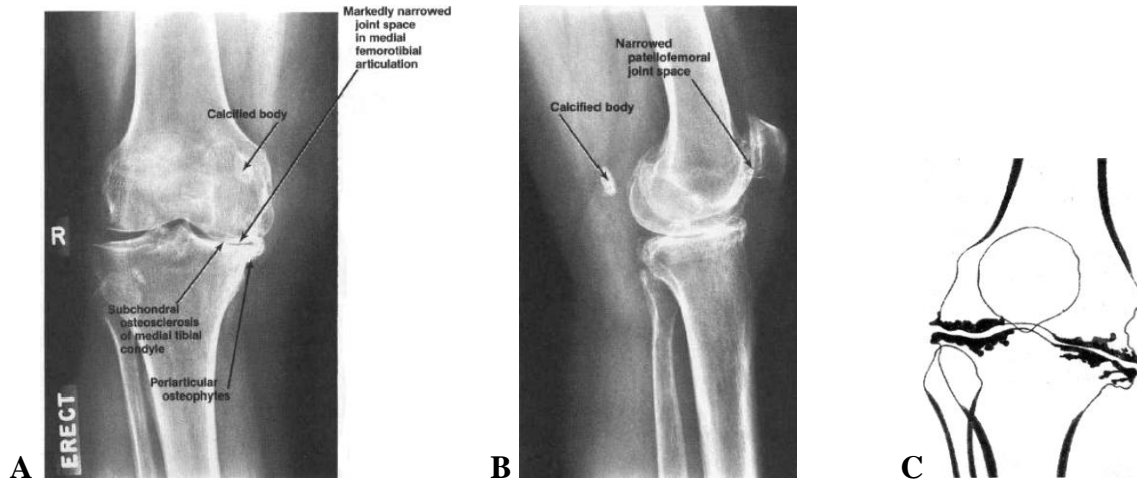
The frontal (A) and lateral (B) radiographs show evidence of severe osteoarthritis of the right knee, x-ray showing serious degenerative disease. (C) Scheme of deforming arthrosis. Markedly narrowed of the joint space, osteoclerosis (subchondral) of articular surfaces, marginal bone peaks — periarticular osteophytes (lateral and medial)
